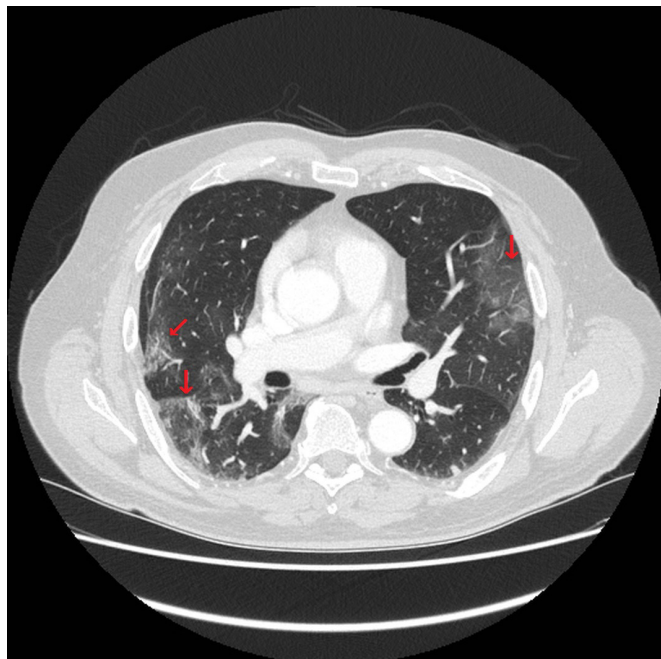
CT scan in axial plane showing ground glass opacities extending to the pleura (arrows).
